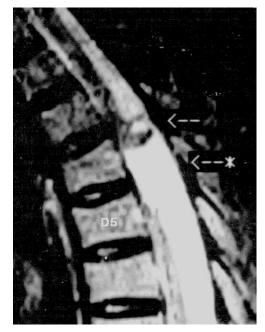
T2-weighted sagittal sequence. The lesion is present posterior to cord pushing it anteriorly, enhancing on contrast administration. The oedema can be seen surrounding the lesion.
